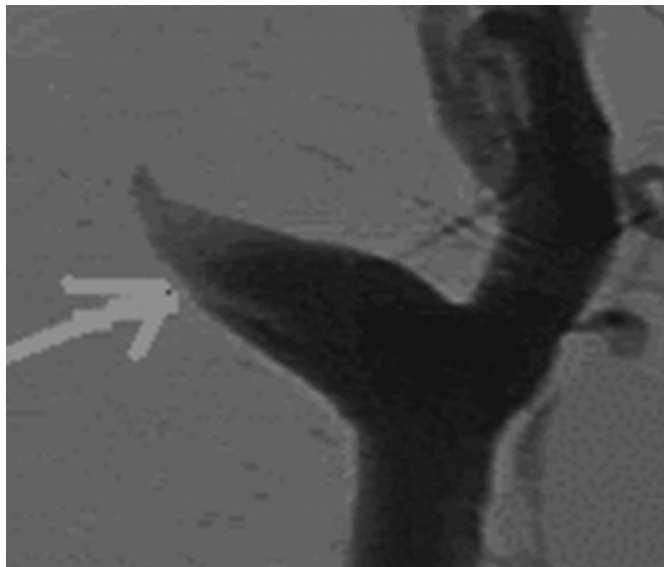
MRI showing right internal carotid dissection
